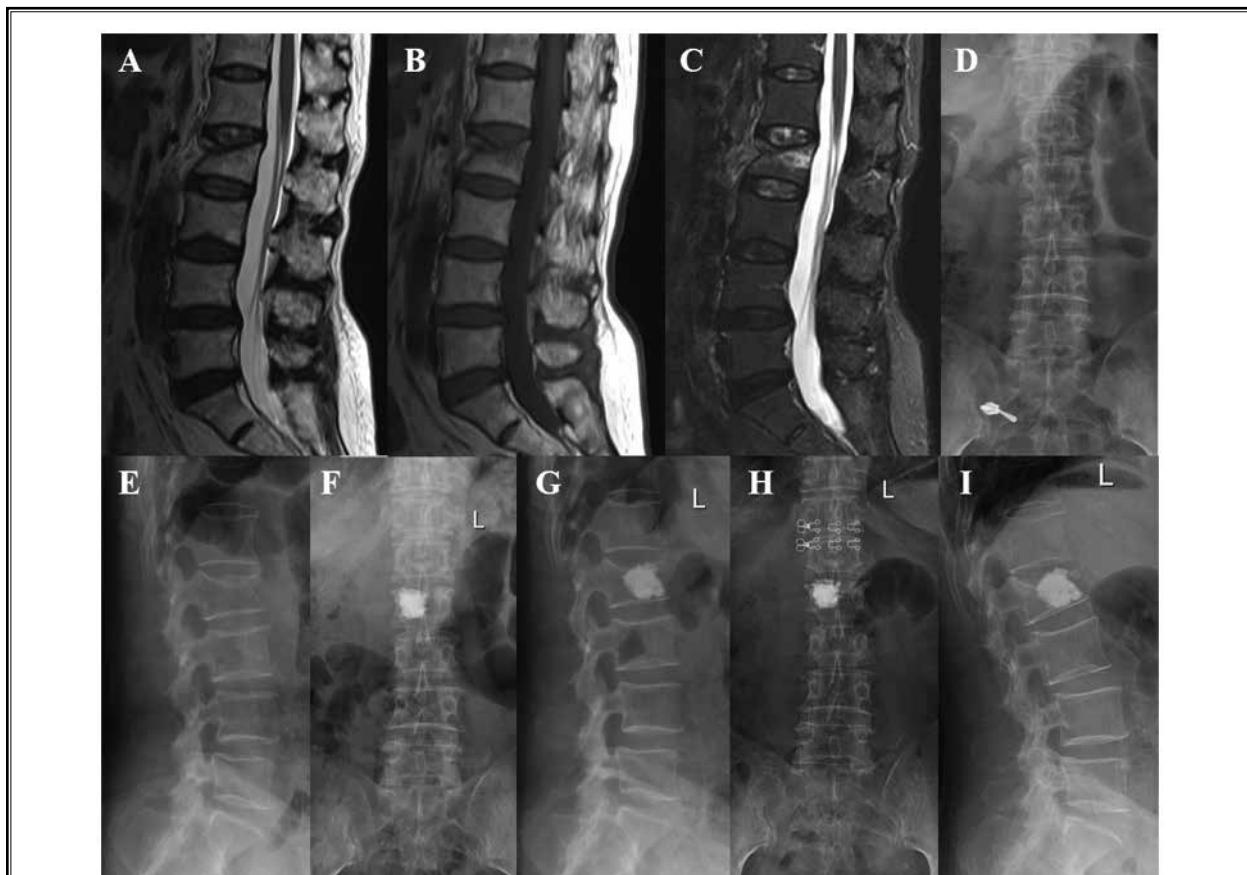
The imaging data of a 70-year-old woman showed L2 vertebral compression fracture. However, she complained of ASIC pain, with a VAS score of 6. After surgery and 18 months of follow-up, the patient's ASIC pain was significantly improved, and the VAS score was 1 and 0 points, respectively. (A–C) Preoperative MRI; (D, E) preoperative lumbar radiograph; (F, G) lumbar radiograph 3 days after operation; (H, I) lumbar radiograph 18 months after operation.
